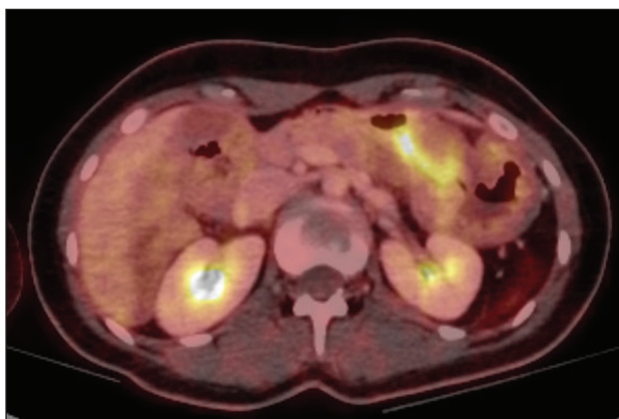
FDG PET CT-scan: malignancy at the level of the stomach.
